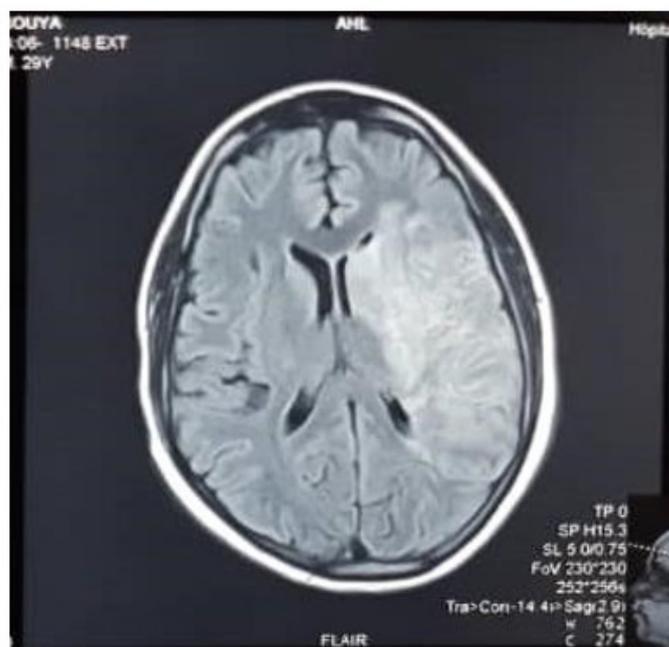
Brain MRI: left total sylvian ischaemia with haemorrhagic remodelling within it.
